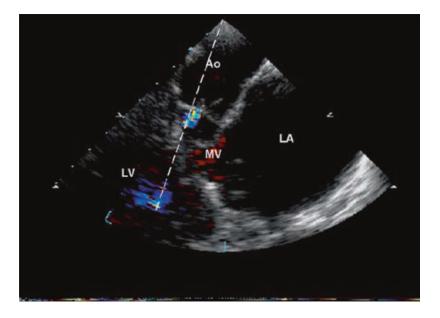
Mid-esophageal long axis view of the aorta (AO) at 124° multiplane angle, in a patient with severe aortic regurgitation (AR). *Left: prolapse* of the conjoined right-left cusp of a non-calcified *bicuspid valve*. *Right*: color Doppler image, showing that the AR jet is deflected
